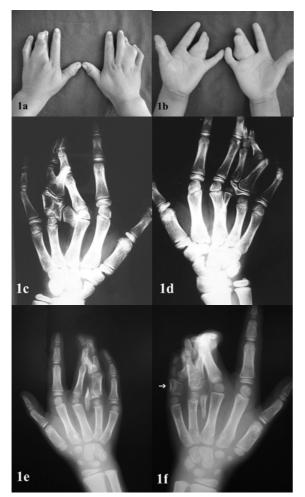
Typical SPD. a).Dorsal appearance. b).Palmar sides. c).X-ray of left hand, complex fusion between the bones. d).X-ray of right hand, clino-camptodactyly of fourth finger. e). Note the delta-shaped epiphysis in duplicated proximal phalanges. f). Delta phalanx (arrow).
